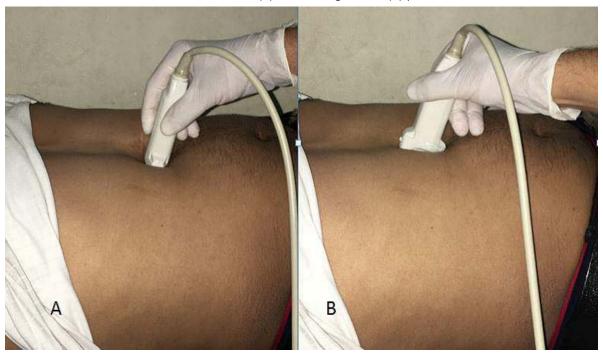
Ultrasound scanning with Linear Probe showing the position of the Linear probe in the epigastric region, in transverse (A) and in longitudinal (B) plane
